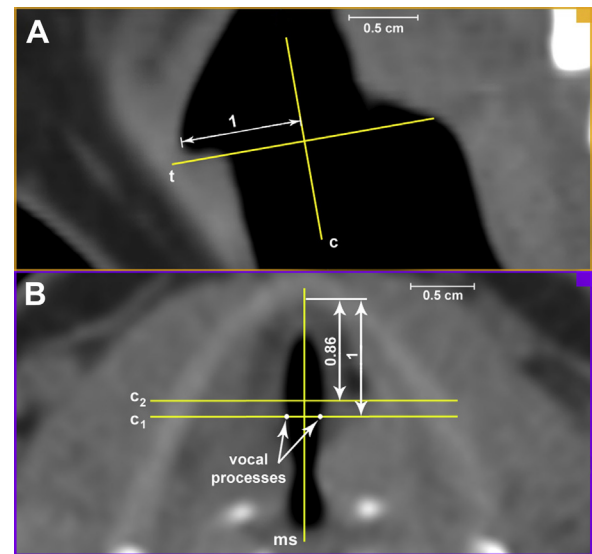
The CT mid-sagittal (A) and the transverse (B) slice demonstrating the adjustment of the coronal plane c . Labeling: c_1 , position of the coronal plane at the level of vocal processes; c_2 , position of the coronal plane used for the measurement of vocal fold vertical thickness and cross-sectional area; ms , position of the mid-sagittal plane; t , position of the transverse plane. The distance labeled by number 1 indicates the reference vocal fold length, that is, the normalized distance between the anterior apex of the lowest part of the laryngeal ventricle and the vocal processes.
